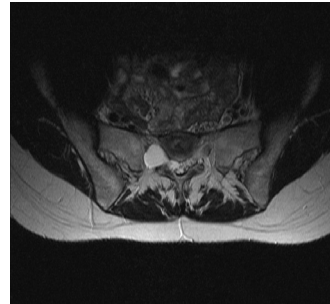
MRI axial T2WI: a CSF-filled cystic lesion, 1.5-1.8 cm in diameter, sitting opposite S2.
